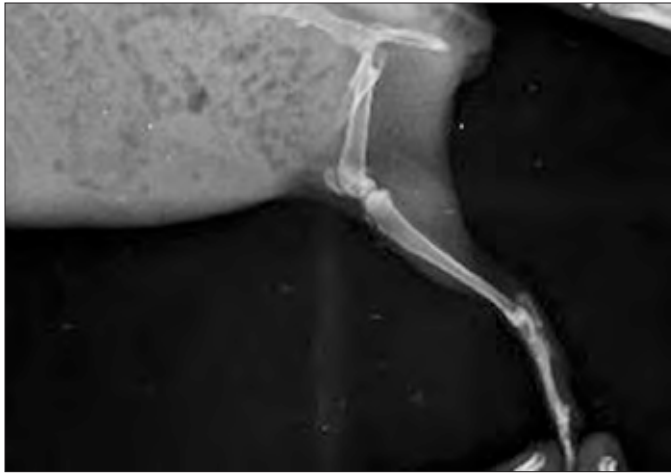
Mediolateral radiograph showing complete oblique diaphyseal fracture of proximal third of right femur bone.
